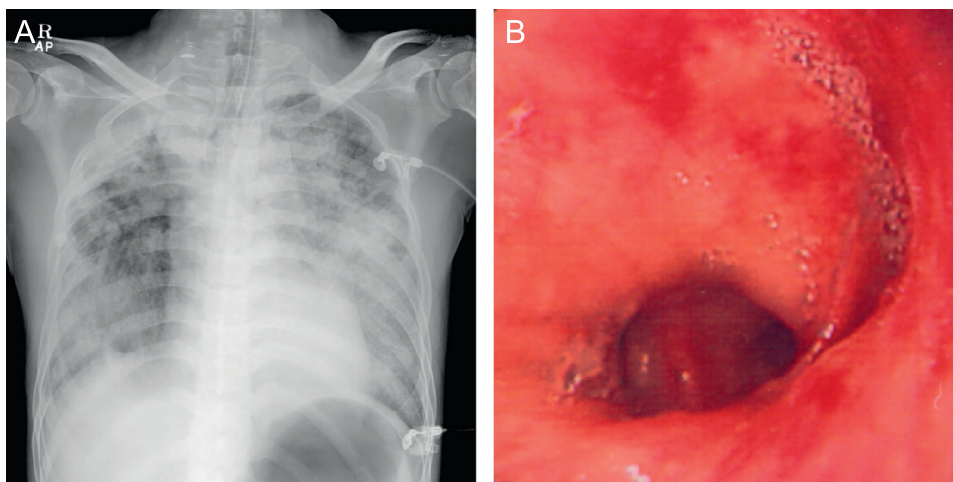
(A) On admission, a chest X-ray revealed pulmonary edema and hemorrhage. (B) Bronchoscopy showed a pulmonary hemorrhage and mucosal swelling in both lungs.
